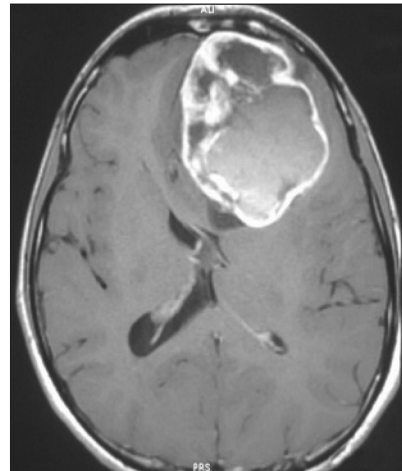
MRI brain showed a well-defined, lobulated, intra-axial mass lesion in the left frontal lobe. On post contrast study, the lesion showed thick peripheral enhancement with perilesional edema and mass effect on the underlying left lateral ventricle
